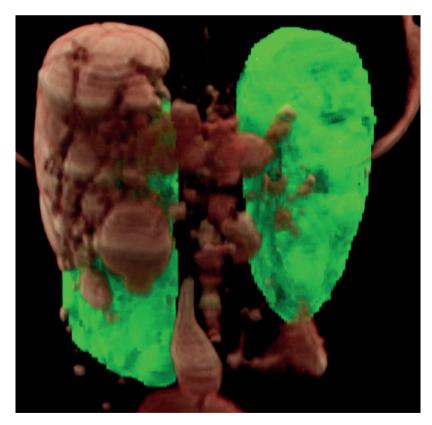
Volume-rendered CT exam
